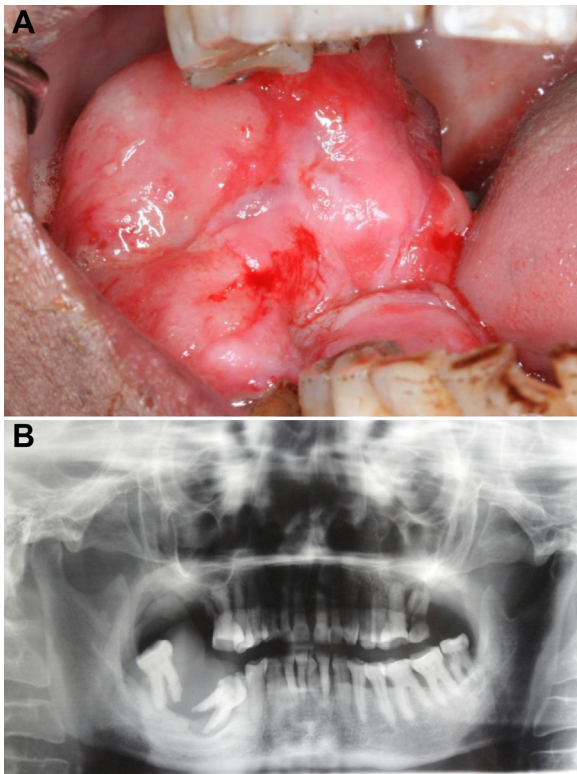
Clinical and radiographic features of the soft tissue masses. (A) Two pedunculated soft tissue masses were observed on the right lower gum. (B) The panoramic radiograph demonstrates homogeneous, slightly radiopaque soft tissue mass occupying the right posterior mandible, involving the right lower first and second molars which show no bony support.
